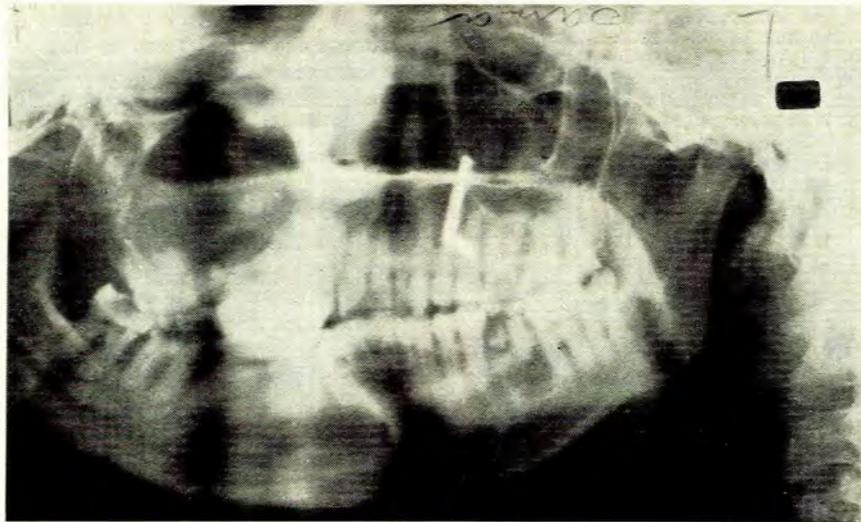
Orthopantomograph of maxilla in case 2, showing a dental cyst distending the right antrum.
